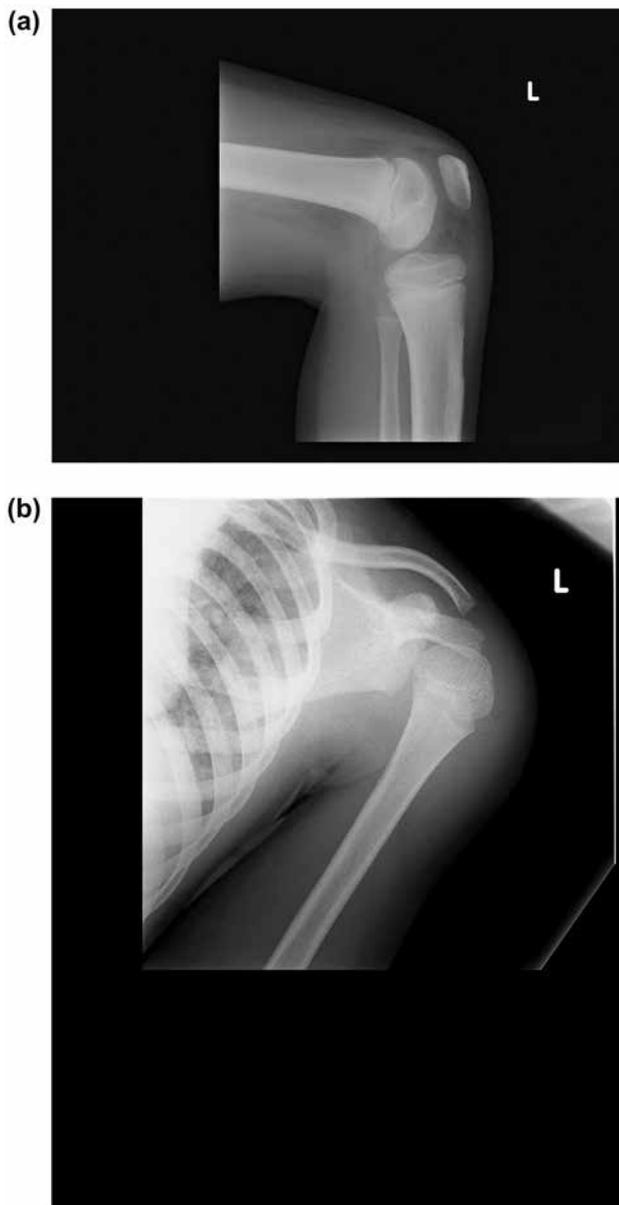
(a) and (b) Radiographs of left knee and shoulder.
